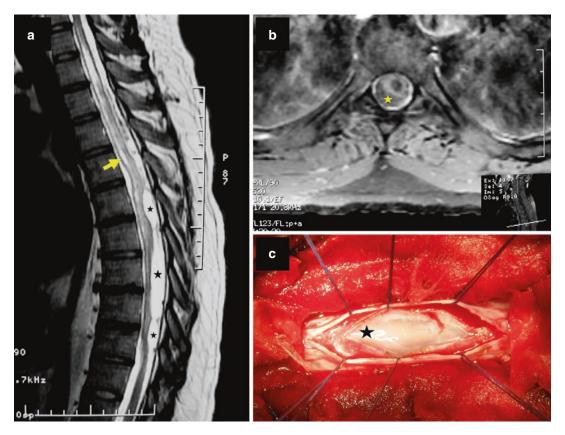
Sagittal spinal T2-weighted MRI (a), axial spinal T1-weighted MRI after gadolinium injection (b), and operative view (posterior thoracic approach) (c). There is
